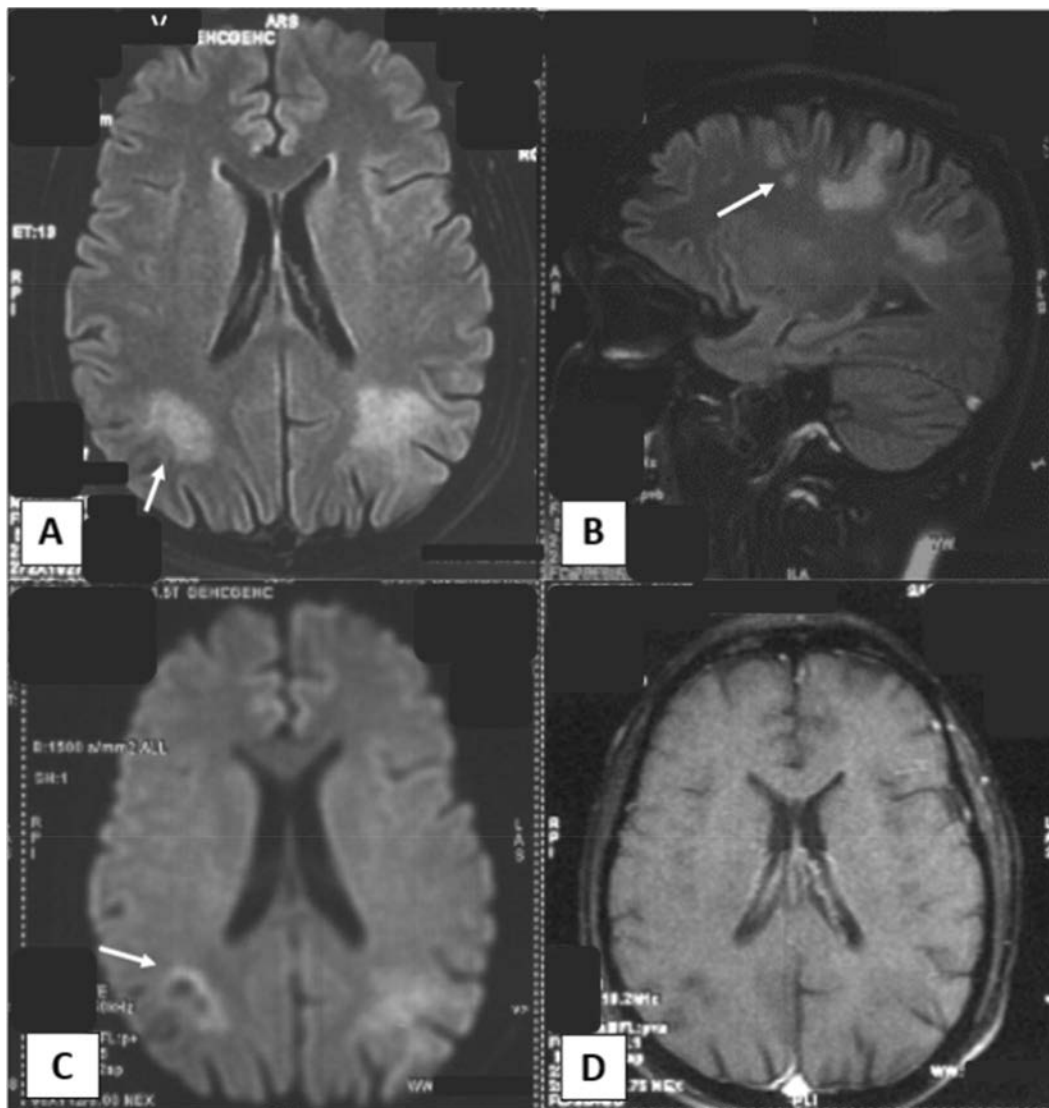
Magnetic resonance image of the brain (three weeks before admission). (A) Axial and (B) sagittal fluid-attenuated inversion recovery (FLAIR) images showing hyperintense focal and confluent lesions involving bilateral parietal, left temporal deep/subcortical white matter without mass effect. These lesions were hypointense on T1 (not shown here); white arrow in (A) shows involvement of subcortical U fibers, and white arrow in (B) shows “milky way sign” (multiple punctate FLAIR hyperintense lesions surrounding the main lesion), which are typical for patients with progressive multifocal leukoencephalopathy. (C) Diffusion-weighted image shows peripheral rim of diffusion restriction (white arrow; “rim and core pattern”). (D) No contrast enhancement of lesions is seen after gadolinium administration. The susceptibility-weighted image did not show blooming, and magnetic resonance angiogram was normal (not shown here).
